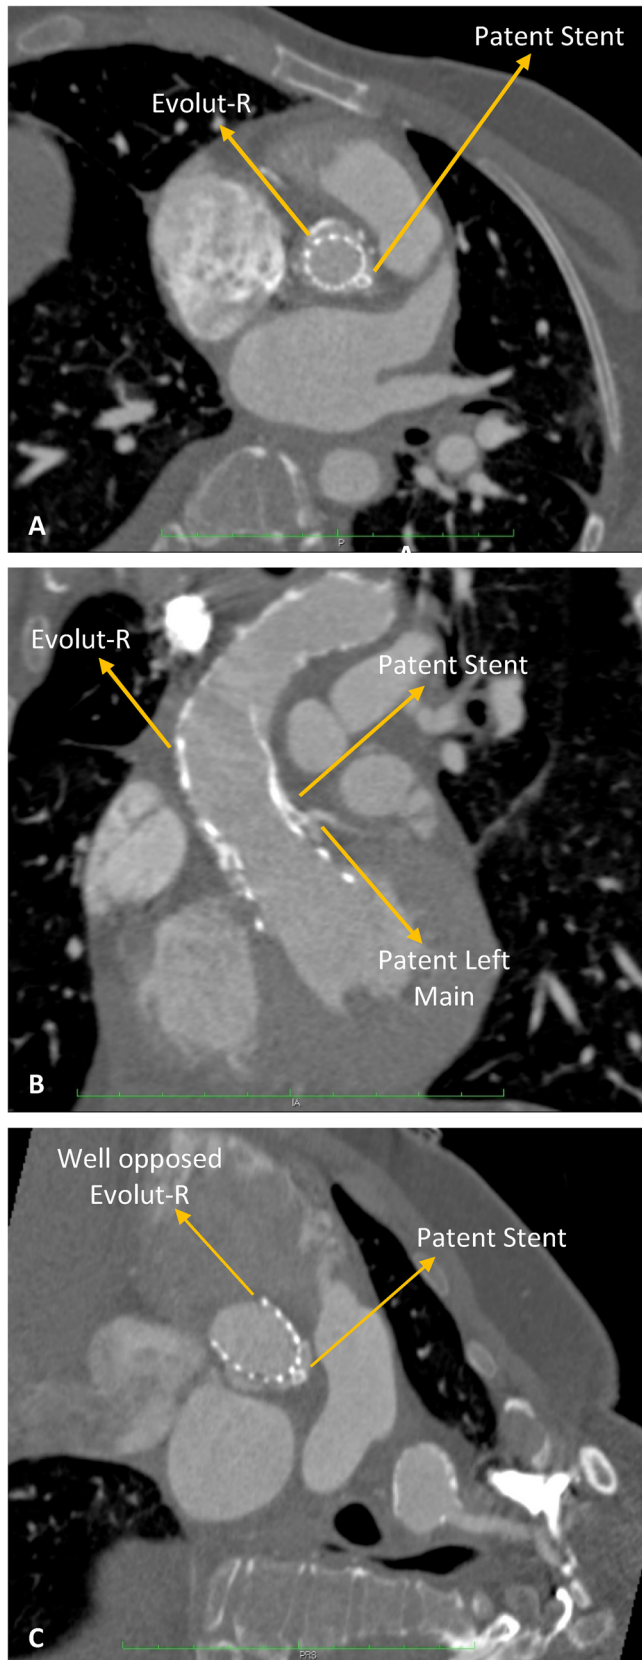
(A,B,C): CT Aortogram at 1-month follow-up shows well deployed Evolut-R & patent stent.
